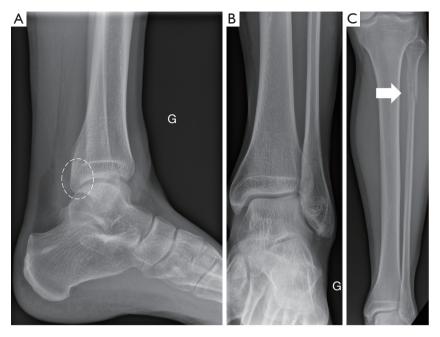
Left (G) ankle radiographs of case 1 at day 1. (A) Lateral left ankle radiograph showing the posterior malleolus fracture (white circle in dashed line). (B) AP left ankle radiograph showing a mortise in an anatomical position and the absence of tibio-fibular diastasis. (C) AP left leg radiograph showing a proximal fibula fracture (white arrow). AP, anterior-posterior.
